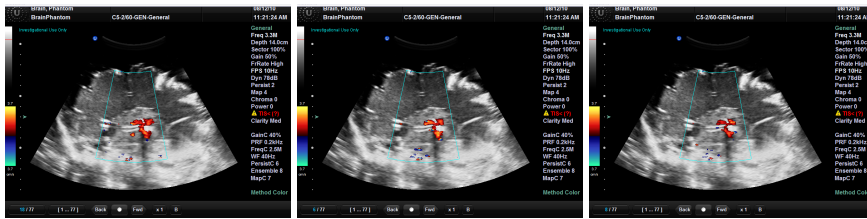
These Doppler Ultrasound images show the signal at the connection points, where the tubes are connected.
